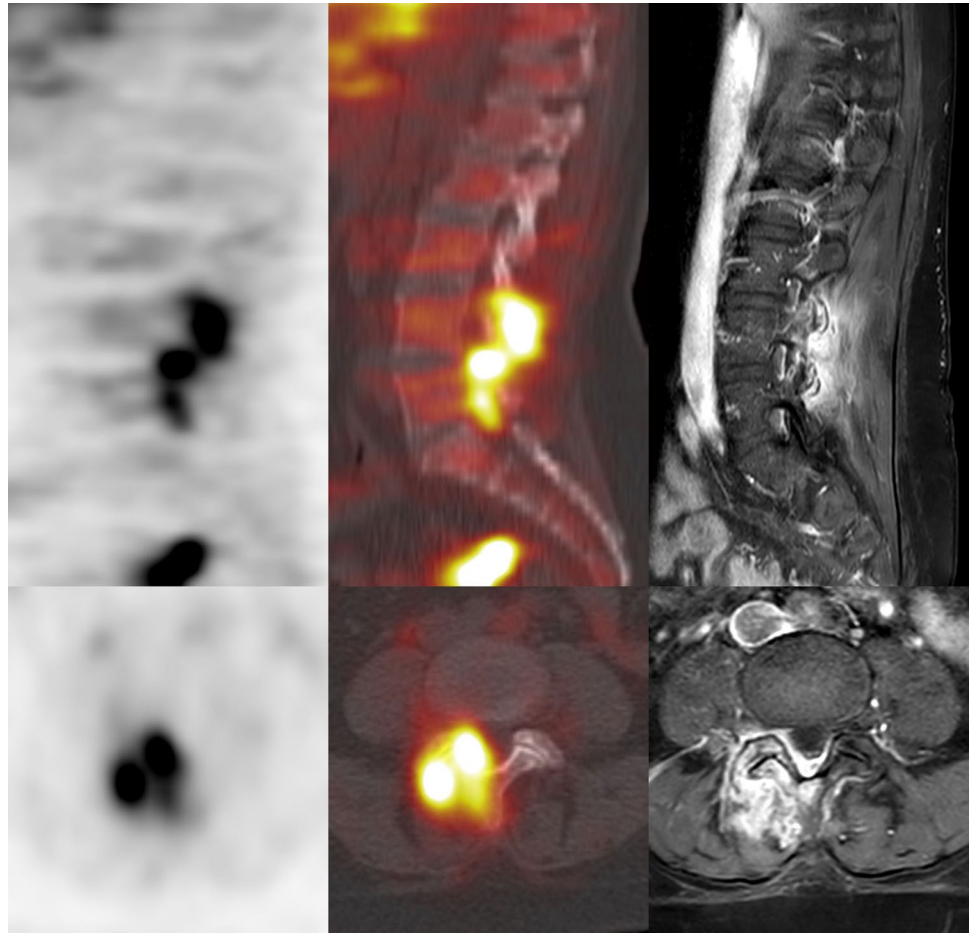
Septic facet joint arthritis. A 55-year old woman with a history of sigmoid carcinoma with liver and lung metastases and a recent *Enterobacter cloacae* bacteremia from an infected peripherally inserted central catheter (PICC), now presents with fever without localizing symptoms. Repeated blood culture is negative. [^{18}F]FDG PET/CT shows increased uptake around the facet joints at level L3-L4 and L4-L5 on the right side (sagittal and axial PET and fused PET/CT images at left and middle panels), suggestive of septic arthritis. MR imaging performed the same day for evaluation of epidural extension (sagittal and axial T1-weighted gadolinium-enhanced images at right panel) confirms enhancement in the facet joints and surrounding soft tissues and an epidural abscess extending from level L3 to level S1
